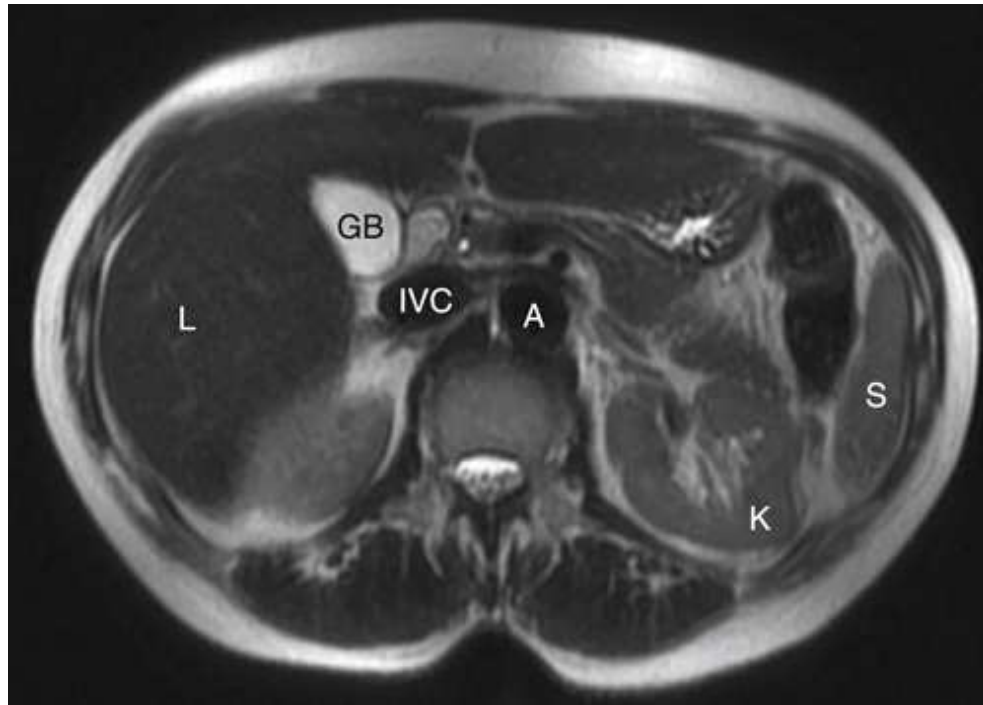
T2-weighted image of an abdomen showing the flow void produced by flowing blood. A, Aorta; GB, gallbladder; IVC, inferior vena cava; K, kidney; L, liver; S, spleen.
